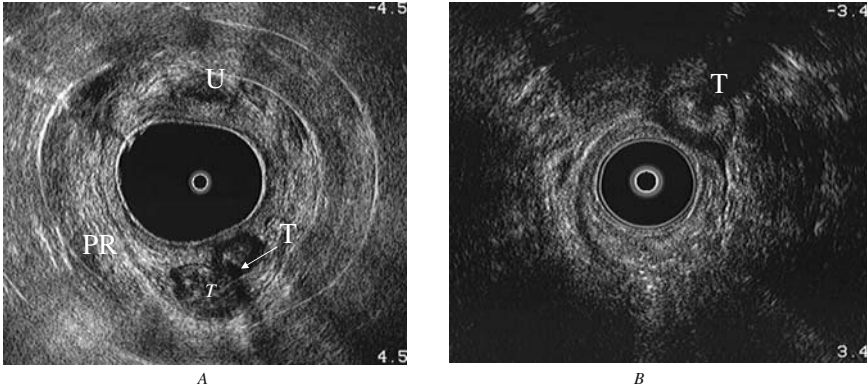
(ii).1. A. Sixty-seven year old female with a palpable benign expression (T) in the rectovaginal septum seen on transvaginal ultrasound using a B&K 360 degree rotating 10 megahertz probe. Orientation: U, urethra; PR, puborectalis sling. B. The same, well-delineated expansion (T) on endoanal ultrasound, compressing the external anal sphincter.
